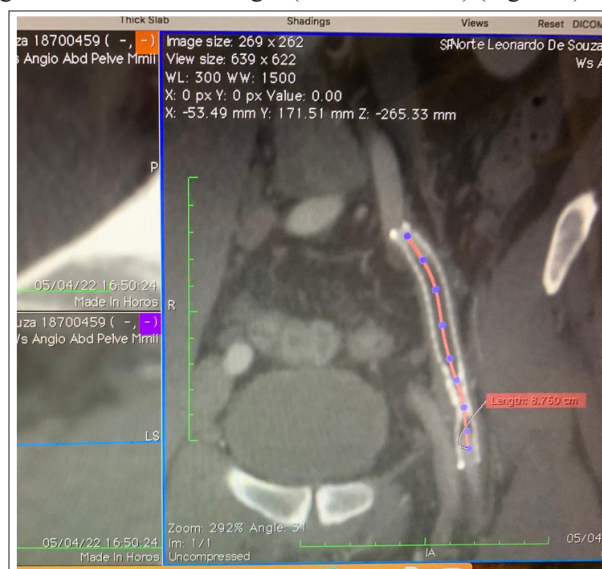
Computed Tomographic Angiography Demonstrating the Length of the Dacron and the Drug Eluting Stent Occlusion
